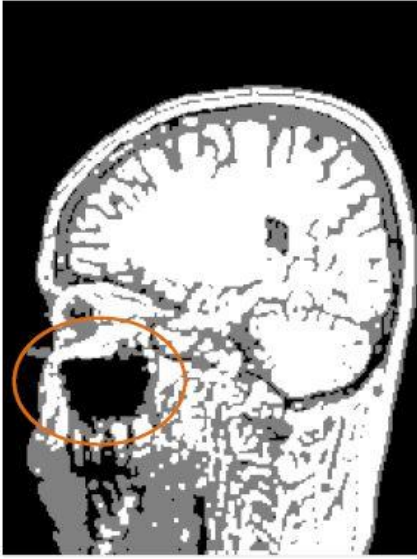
2D MRI cortex segmentation with a support of Otsu method with two multilevel.
